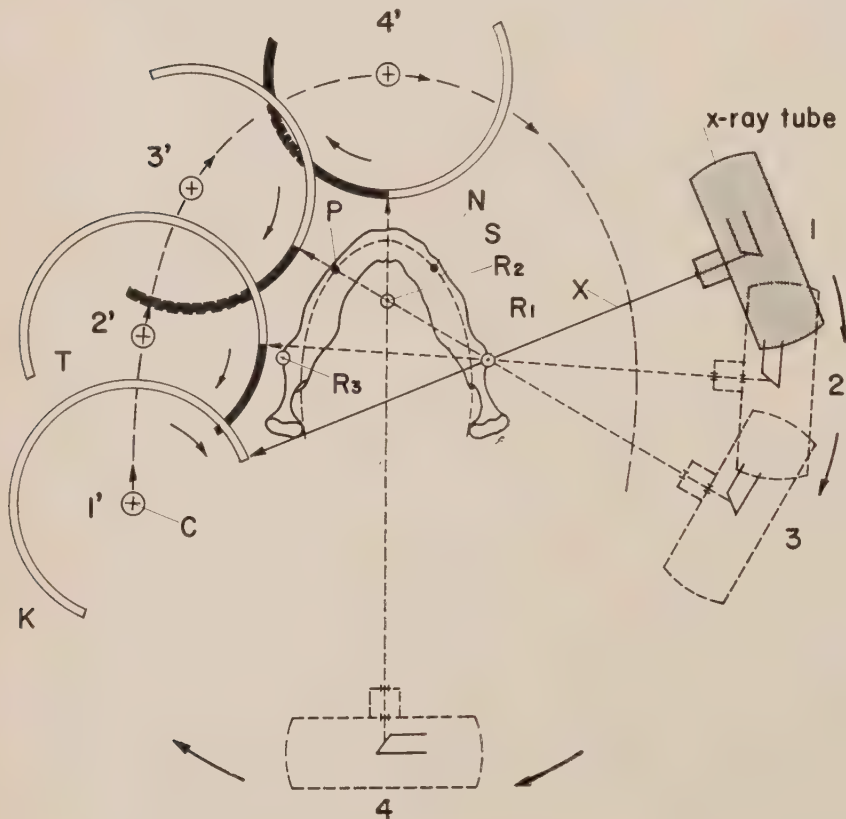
Combined concentric and eccentric tomographic principle, with three rotational centres; one for the left buccal segment, one for the anterior segment, one for the right buccal segment. The orthopantomograph works on this principle, changing axes in the cuspid-first bicuspid regions. The x-ray beam turns around rotational centre R1 first to radiograph the left side. At the first bicuspid-cuspid region, the axis changes to R2 to radiograph the anterior maxillary and mandibular portions; structures from P to N are in focus. As the beam reaches S, it swings over to R3 rotational axis, and projects an image of the right side on the rotating film cassette, with all structures from S to the right condyle in focus. (After Paatero)
